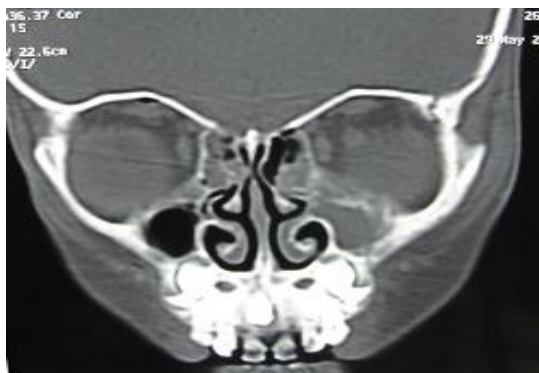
(a) Orbital trauma due to fall from height, (b) 3 Dimensional CT Scan showing fracture of temporal bone & lateral orbital wall, floor of left orbit & maxilla.
